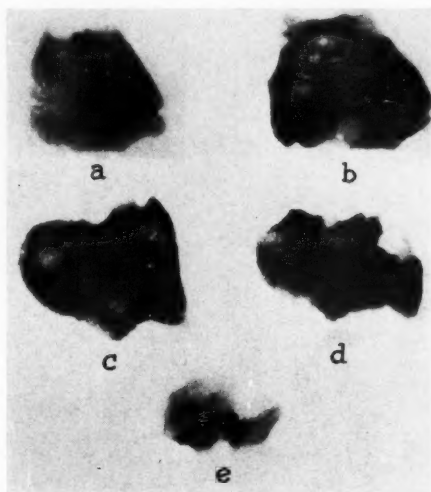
Roentgenograms of five sagittal slivers of the excised right cuboid bone, arranged serially from (a) the most medial section (cuneiform surface) to (e) the most lateral section. The numerous and variable sized radiolucent areas represent localized multiple abscesses. Some of the large defects extend through the entire thickness of the tarsal bone. The bone is densified even in these thin slivers and the osteosclerosis is exaggerated about the larger radiolucent foci. The articulating and non-articulating surfaces show considerable irregularity.
